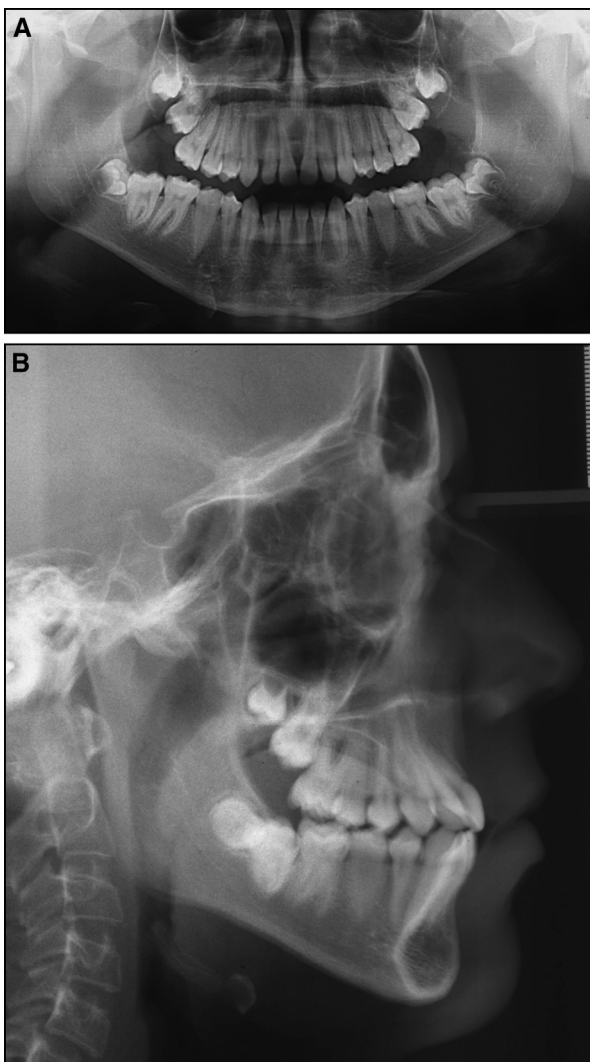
Pretreatment radiographic records in patient 2: A, panoramic radiograph; B, lateral cephalogram.
